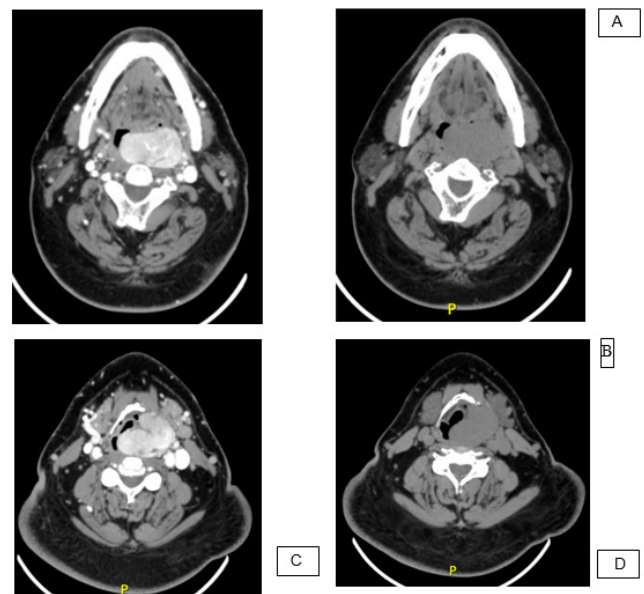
CT showing the tumor at a mandible level (A and B) and Hyoid bone level (C and D) It is remarkable how it changes with contrast imaging.
